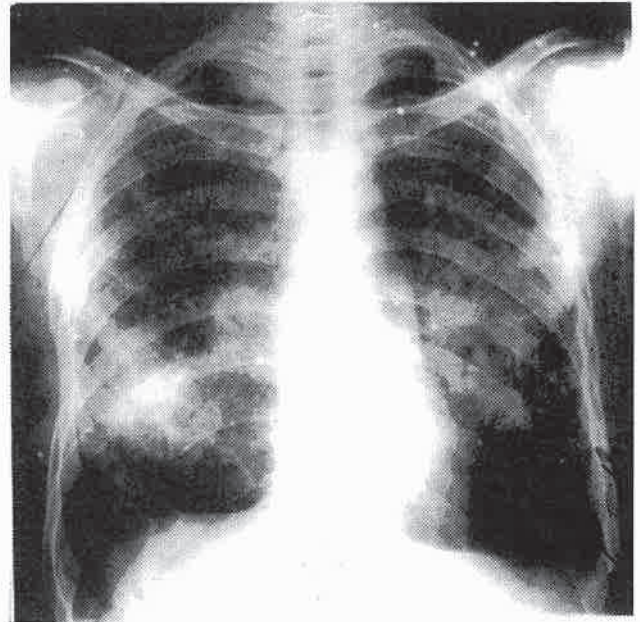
Chest x-ray of a patient with complicated silicosis.
